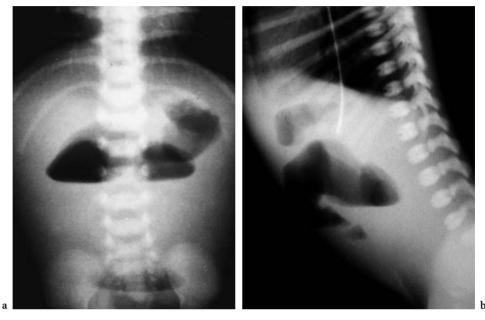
Jejunal atresia. Anteroposterior (a) and lateral (b) upright radiographs show a few central air-fluid levels indicating high obstruction
